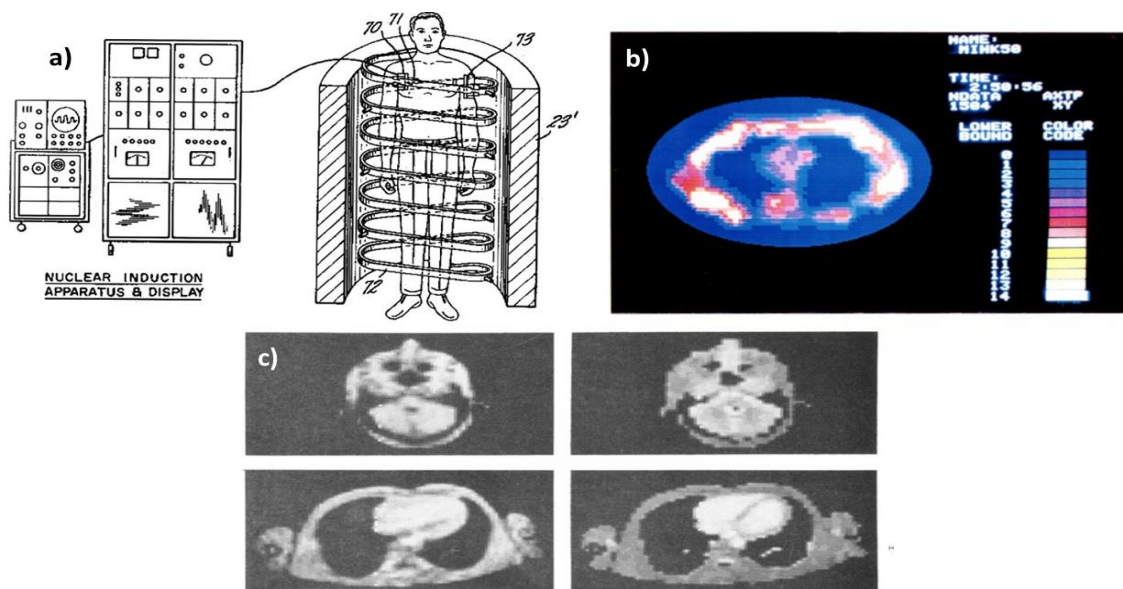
In a), there is the first MRI imaging apparatus filed by Damadian reproduced [16]. Images b) shows the axial reconstruction of the signal (total scan time 5 hours). In c), one of the first images obtained by Edelstein and Hutchinson showing an axial slice of brain and thorax (Reproduced with permission from [10]).
